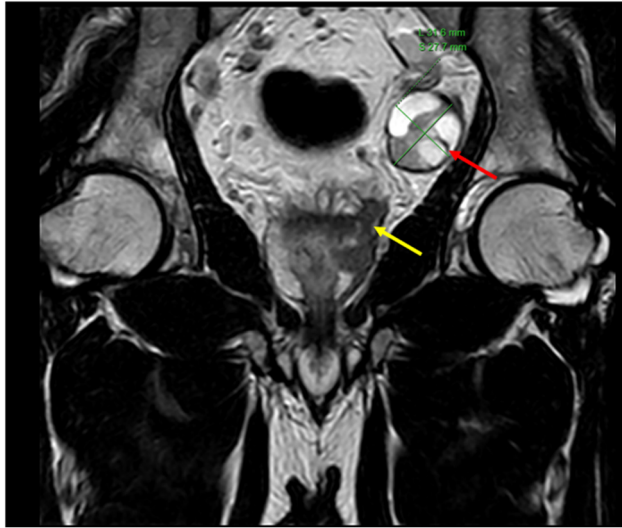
A prostate MRI showed a T2 hypointense lesions which invasion to seminal vesical (yellow arrow) and left common iliac lymph node (red arrow).
